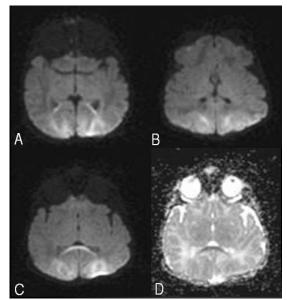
DWI (A-C) and ADC (D) showing diffusion restriction in parieto-ocipital white matter and splenium with low ADC values
